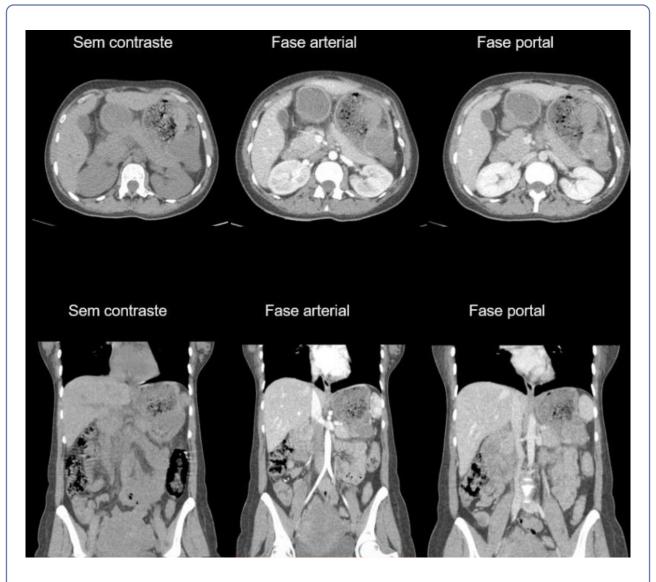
CT scan of the abdomen with and without contrast. Expansive lesion in the middle portion of the greater curvature of the body of the stomach, with an exophytic transmural component, with heterogeneous enhancement. Measuring $5.4 \times 3.6 \times 4.2$. In addition to hyperdense material in the gastric cavity that may correspond to hematic material.
